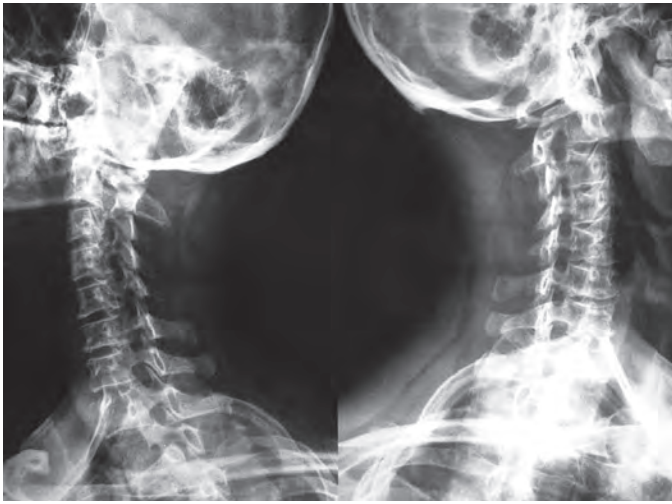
Oblique cervical spine X-rays showing foraminal stenosis by osteophytes mainly at left C3/4
